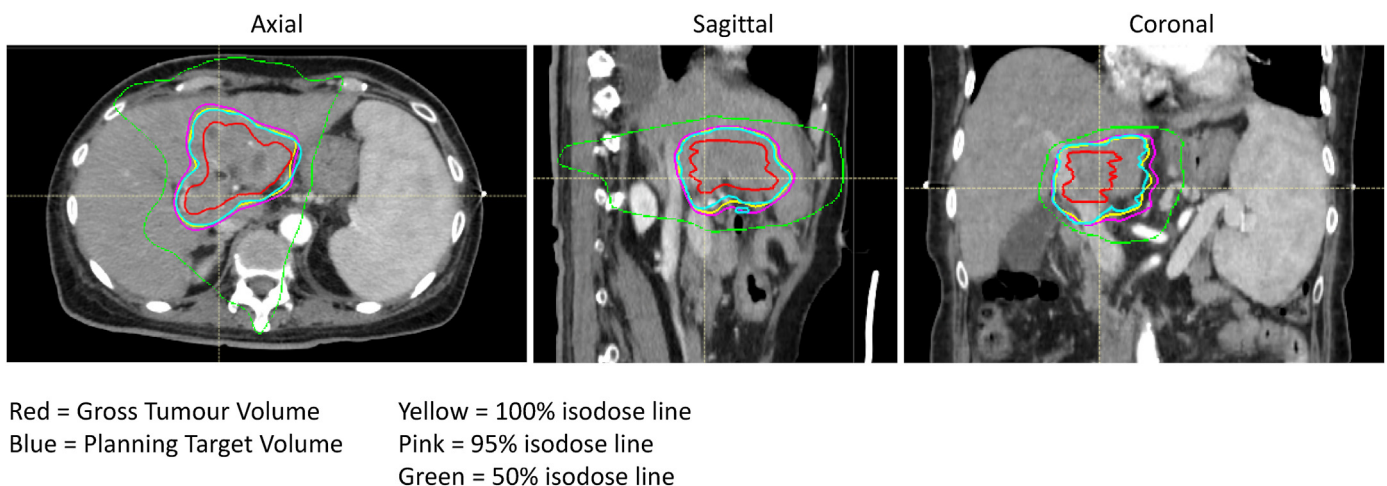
Axial, sagittal and coronal cuts through an arterial phase of a computed tomography linear accelerator plan receiving 3000 cGy in five fractions for hepatocellular carcinoma.
